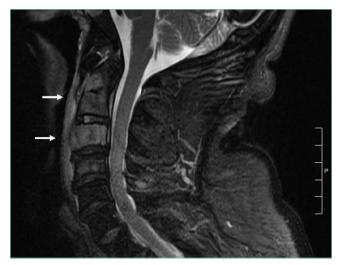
Magnetic Resonance Imaging of the Cervical Spine. Imaging reveals bony lytic lesions with notable cortical breakthrough of the C2 and C3 vertebrae into the prevertebral space (arrows).
